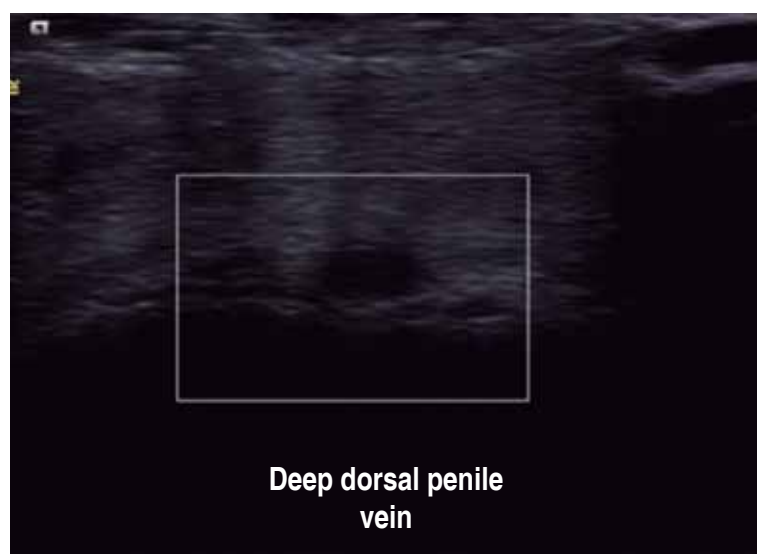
Axial section of deep dorsal vein of the penis by Doppler ultrasound, showing flow absence.
